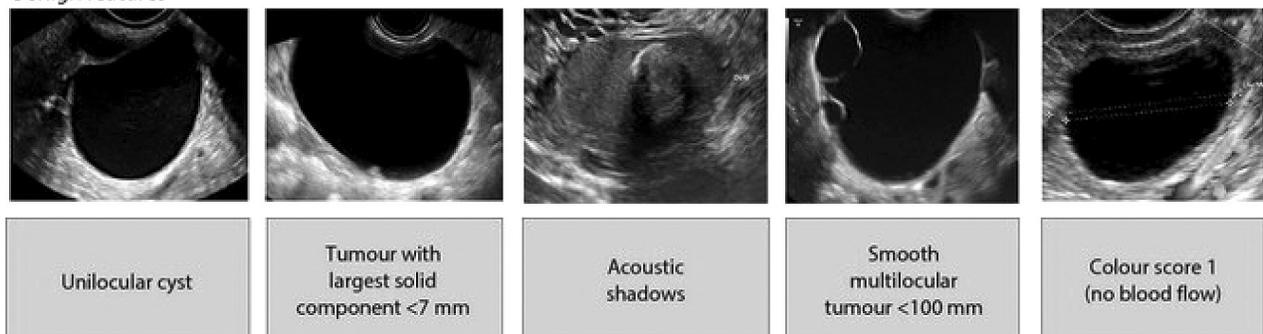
Sonographic features for identifying a benign or malignant tumor using IOTA simple rules
